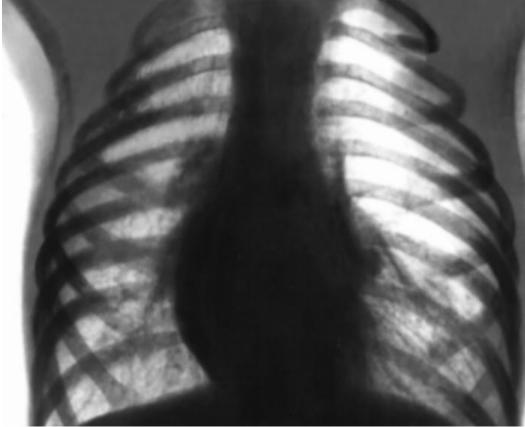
Figure to task 3. X-ray of patient K., 58 years
